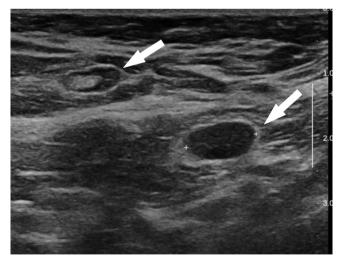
A 48-year-old woman with mucinous carcinoma in the left breast. Axillary US demonstrating suspicious lymph nodes with cortical thickening (arrows) and effacement of the fatty hilum (crosses). The patient received a third dose of the BNT162b2 vaccine in the left deltoid muscle four days before the preoperative axillary US. Ultrasonography-guided fine-needle aspiration of the lymph nodes was negative for malignant cells. Left breast-conserving surgery and sentinel lymph node biopsy were performed, and final pathology revealed no axillary lymph node metastasis. US = ultrasound
